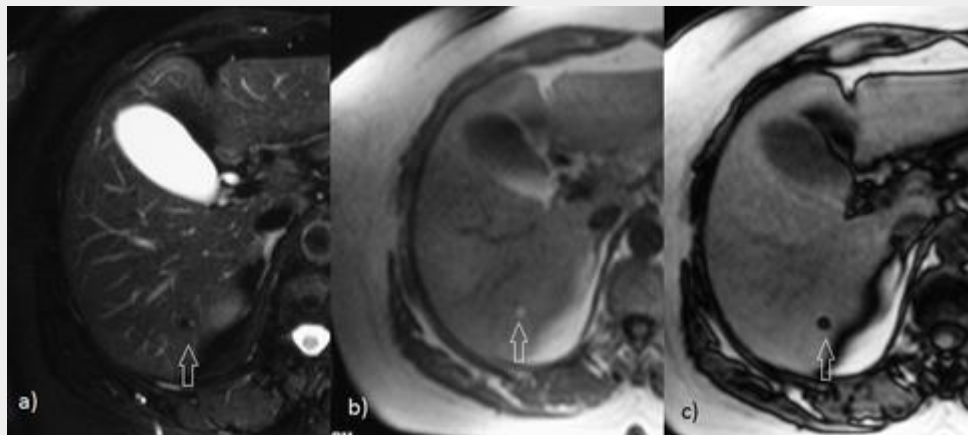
Hepatic lipoma. MRI study showing a tiny nodule on the right liver lobe with low SI on the T2-w FS sequence (a) and hyperintense on the in-phase T1-w image (b); the indian ink artifact around the lesion due to susceptibility artifact in the boundary between the tumor fat and the adjacent liver parenchyma on the out-of-phase image (c) almost obscures it.
